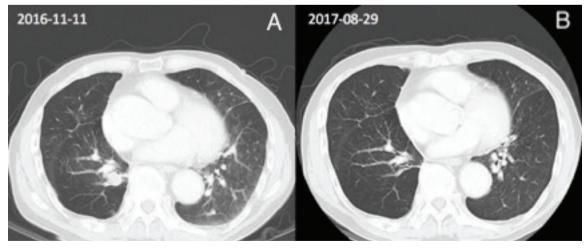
Chest CT images showing lung cancer response to crizotinib. (A) CT image during the second cycle of chemotherapy with cisplatin plus pemetrexed showing a lung mass at the right middle lobe, and (B), CT image taken after treatment with crizotinib for 9 months showing a decreased lung mass compared with the previous image.
